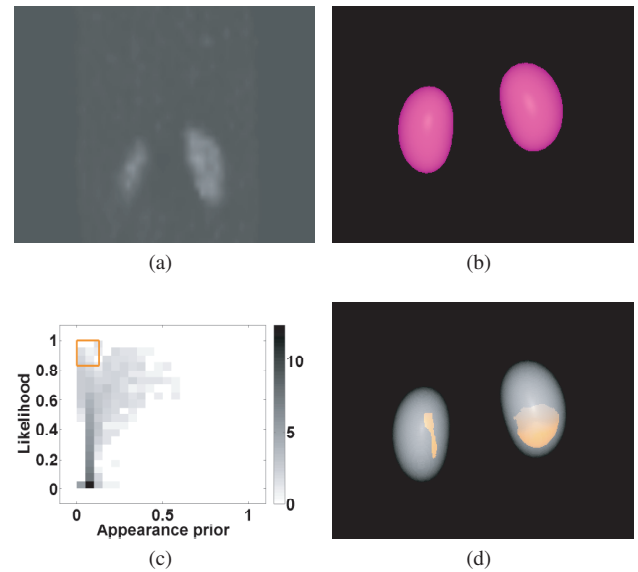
dSPECT case study with abnormal renal behavior in the lower third part of the left kidney. a) 2D coronal slice out of the 4D dataset, b) the isosurface of the maximum likelihood, c) likelihood vs appearance prior histogram, d) selection of disagreement between the likelihood and appearance reveals abnormality in the lower third part of the kidney. The small abnormality in the right kidney was verified to be a result of the PVE which results in low appearance prior.
